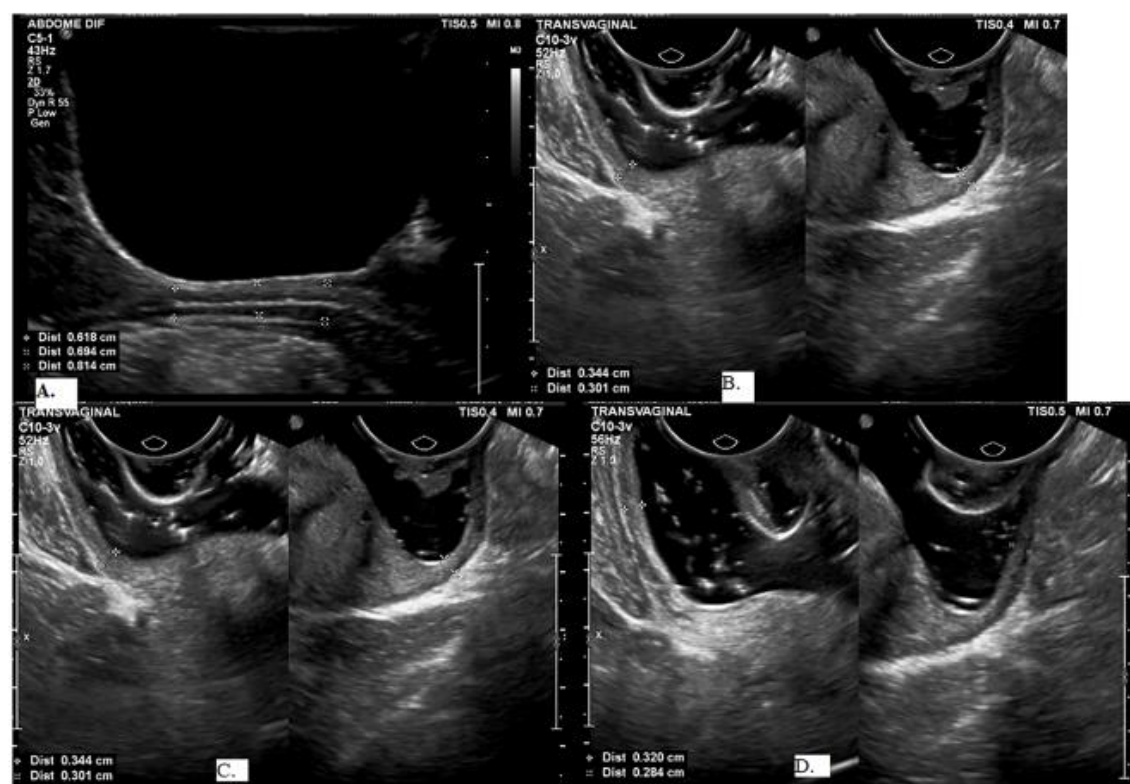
Vaginal wall thickness measurements on transabdominal and transvaginal ultrasounds. A: transabdominal technique, with all portions of the vagina; B: transvaginal technique, proximal vagina; C: transvaginal technique, mid-third vagina; D: transvaginal technique, distal vagina
